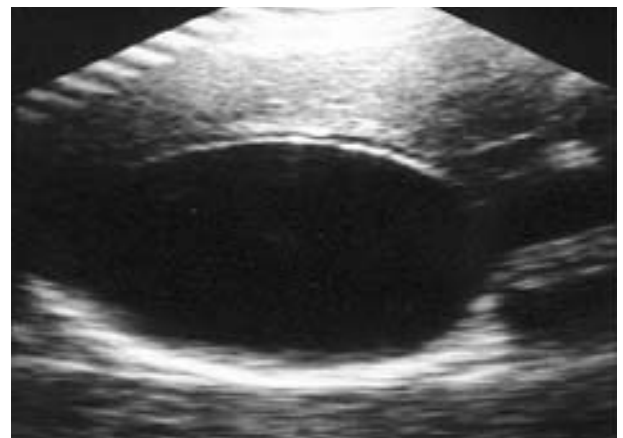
Ultrasonographic image of the hepatic hydatid cyst
